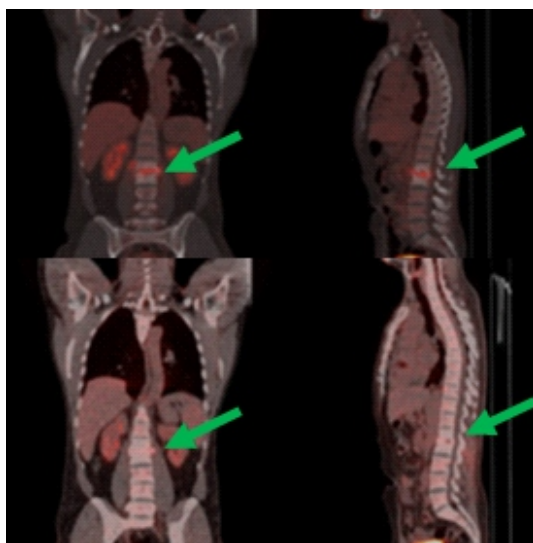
A 38 year old with lumbar region pain and fever. MRI: spondylodiscitis of L1-L2. Vertebral biopsy: infectious spondylodiscitis (S. Epidermidis). Pre-treatment ^{18}F -FDG PET/CT: increased uptake of L1-L2 (SUV max 9.8) and near soft tissue involvement. Post-treatment ^{18}F -FDG PET/CT: decreased ^{18}F -FDG uptake of L1-L2 (SUV max 3.1) that means good response in antibiotic therapy.
